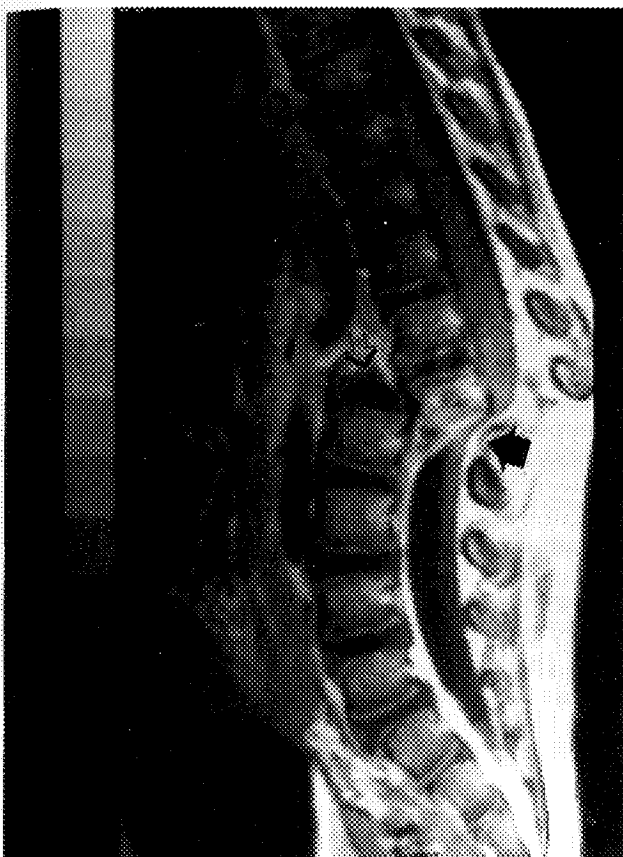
Sagittal T1-weighted magnetic resonance imaging demonstrates the marked spinal cord compression at the level of the fracture-dislocation (solid arrow). The L1-L2 intervertebral disc and the inferior endplate apophysis of L1 have maintained continuity with the body of L2 (open arrow).
